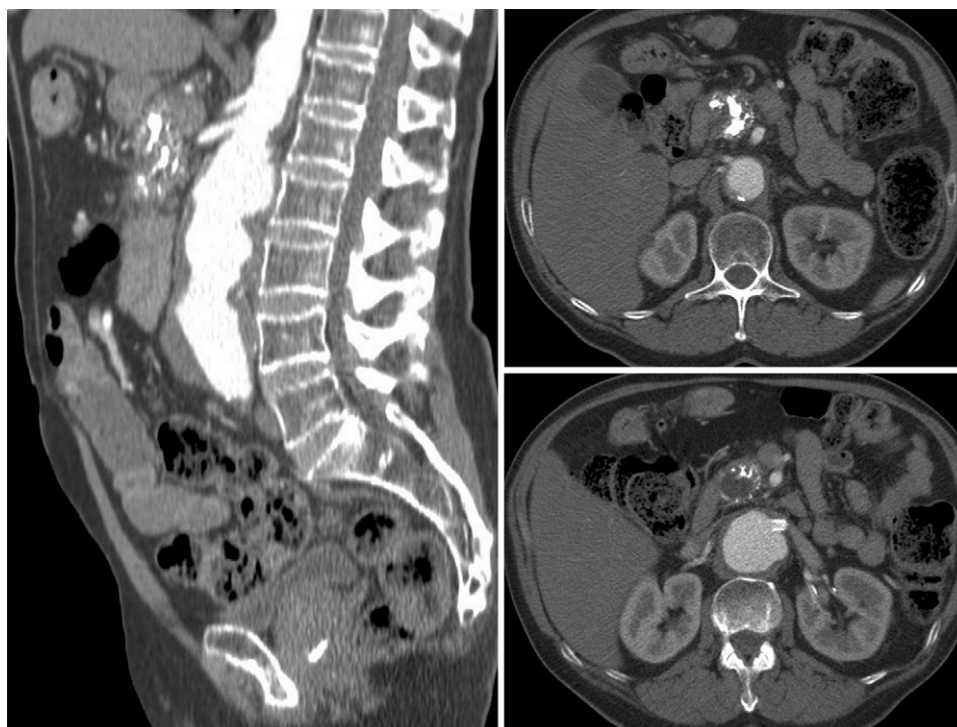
Computed tomography angiography performed 10 weeks prior to the operation. The left panel shows a sagittal section of the aorta, the upper left panel shows a transverse section at the level of the two right renal arteries, and the lower left panel shows a transverse section at the level of the left renal artery with a stent at its origin.
